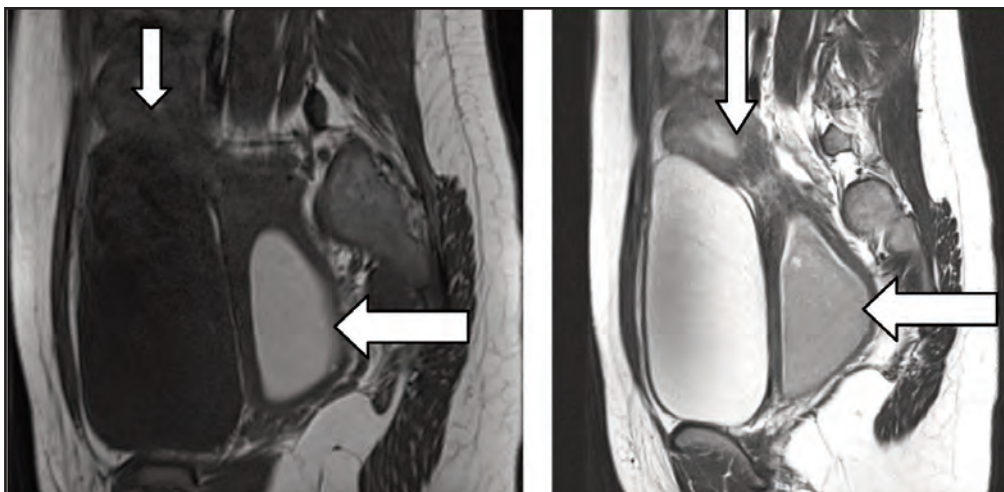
Sagittal T1WI MRI [A] and T2WI MRI [B] show left uterine cavity (thin white arrows) with dilated hemivagina (thick white arrows) showing a hyperintense signal on T1WI (thick white arrow) and hypointense signal on T2WI/T2 shading (thick white arrow), suggestive of blood products within the uterus (hematometra, thin white arrow), and within the vagina (hematocolpos, thick white arrows)
